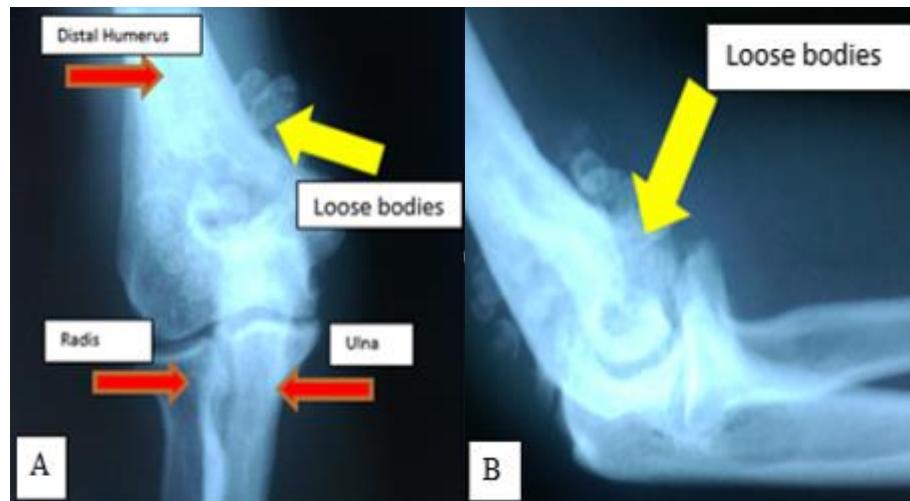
Figure 2A – anteroposterior view and 2B – lateral view. Plain radiographs of right elbow showed numerous radiopaque round and oval loose bodies within the right elbow joints. Note the large loose body within the coronoid fossa region.
